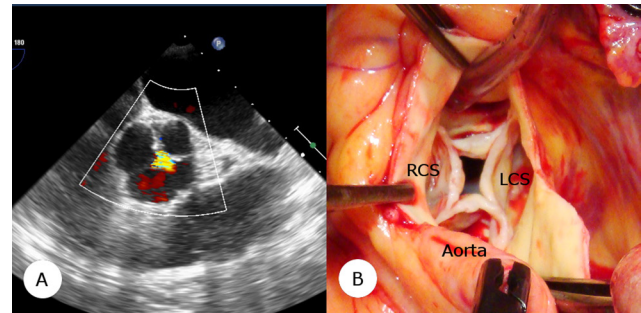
Panel A. Transesophageal echocardiography of quadricuspid aortic valve (QAV), note central AI flow. Panel B. Intra-operative view of QAV. LCS = left coronary sinus; RCS = right coronary sinus.
